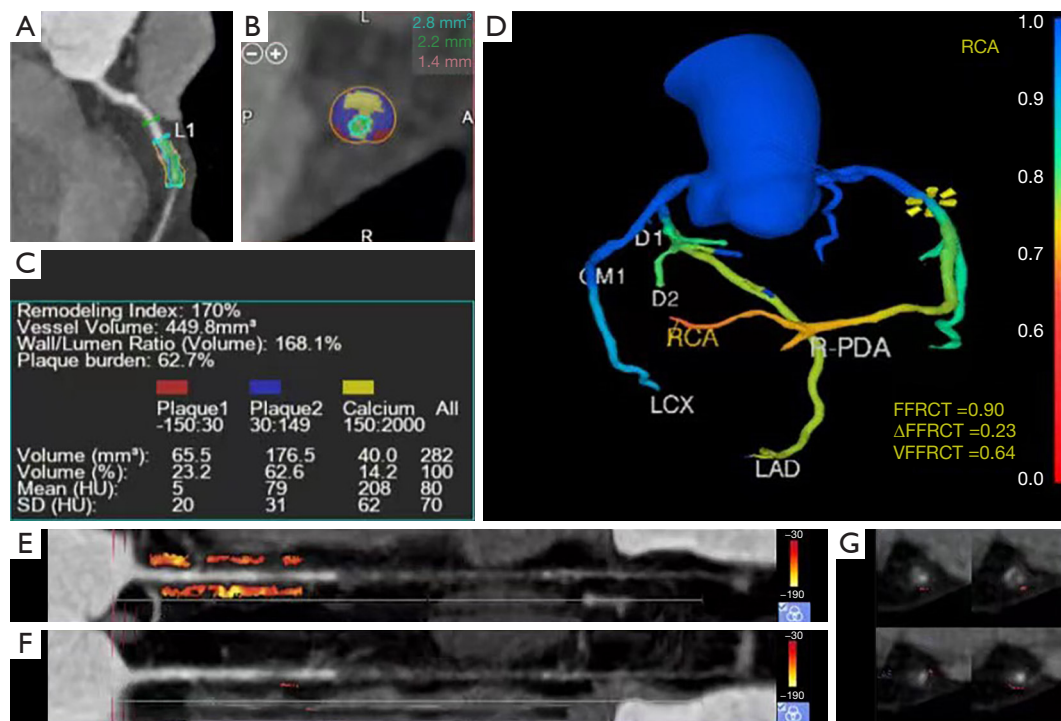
Representative cases. (A) Curved projection reformation map. The lesion area is located between the two blue lines. The green line is the reference point, and the red line is the narrowest position of the lesion. (B) Cross-sectional view of the narrowest position of the lesion. The green area is the lumen and represents the MLA, and the red area is the LAP. The blue area is the FP, and the yellow area is the CP. (C) Plaque analysis map. (D) Hemodynamic characteristic map. (E) Proximal FAI map of the lesion. (F) Lesion-specific FAI measurement map. (G) Cross-sectional view of lesion-specific FAI. Figure shows a typical case of the culprit lesion of ACS. CTA showed RCA lesion diameter stenosis of 58%, lesion length of 1.7 mm, distance from the opening of 45.05 mm, MLA of 2.8 mm², remodeling index of 1.7, wall-to-lumen ratio of 1.68 and plaque load of 62.7% as well as LAP, FP, CP and TP volumes of 65.5, 176.5, 40 and 282 mm³, respectively, with no spotty calcification. FFRCT =0.9, Δ FFRCT =0.23, VFFRCT =0.64. The proximal FAI was -67, and the lesion-specific FAI was -45. At 283 days after CTA, the patient presented with ACS. DS, diameter stenosis; MLA, minimal lumen area; LAP, low attenuation plaque; FP, fibrous plaque; CP, calcified plaque; TP, total plaque; FAI, fat attenuation index; CTA, computed tomography angiography; ACS, acute coronary syndrome; RCA, right coronary artery; FFRCT, computed tomography-derived fractional flow reserve; Δ FFRCT, Delta FFRCT; VFFRCT, vessel FFRCT.
